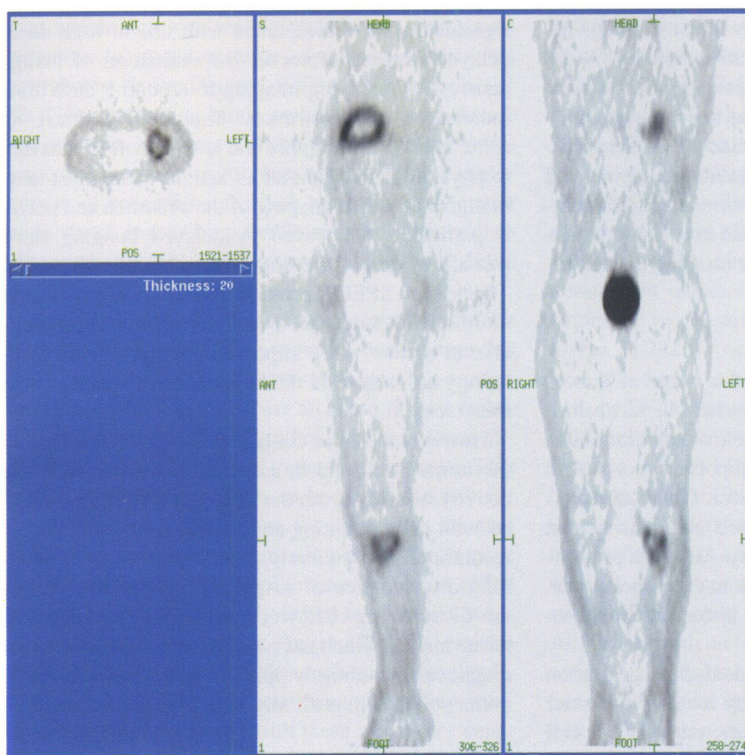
PET scanning with F-18 FDG demonstrates intensely increased activity at the periphery of a biopsy proven osteosarcoma of the proximal left tibia. Whole body screening demonstrates no evidence of metastatic spread.
